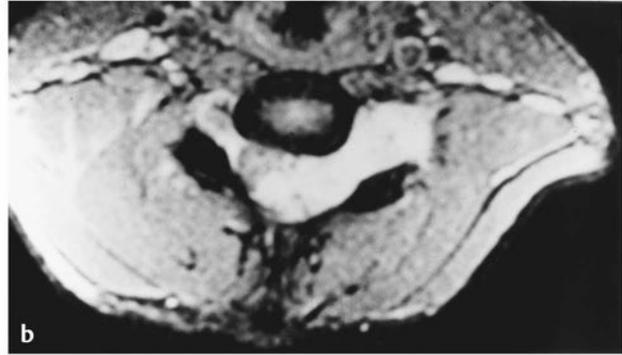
Magnetic resonance images. (a) Multisegmental involvement of the exiting spinal nerve roots by neurofibromas in an 11-year-old boy. These lesions caused no intraspinal compression and have remained stable for more than 8 years without intervention. (b) Intraspinal growth of one of several paraspinal neurofibromas in an 18-year-old boy caused a mild, progressive Brown-Séquard syndrome. This lesion was resected completely, and the patient remains free of disease progression.
